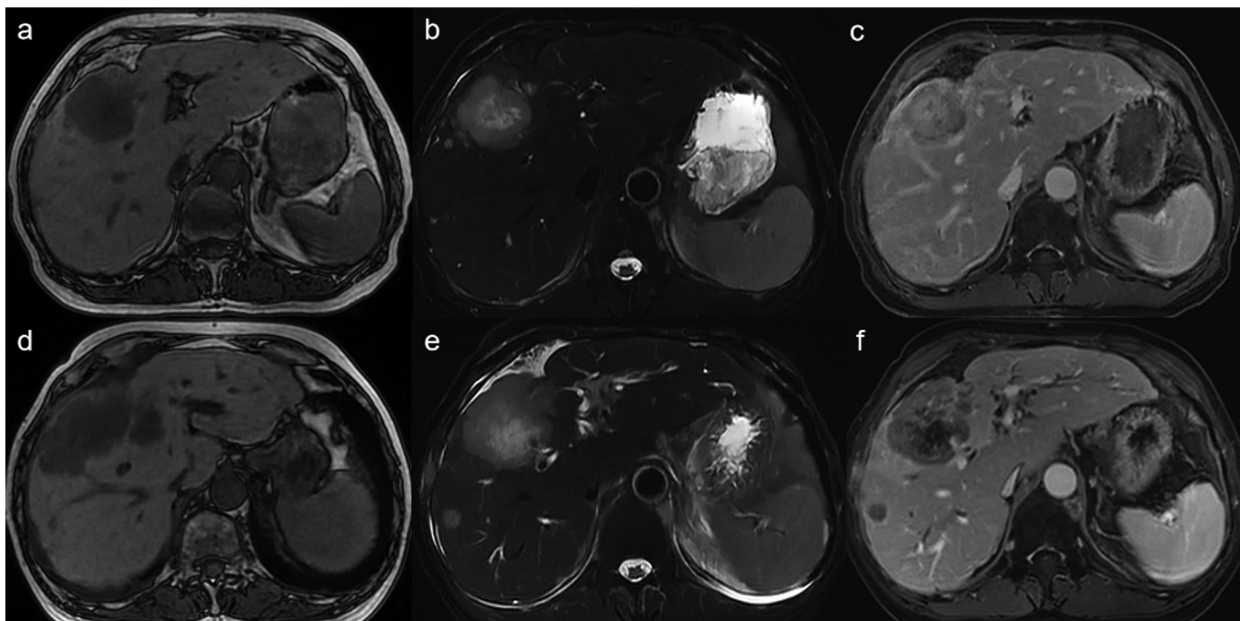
Comparison of efficacy in a patient with prostate neuroendocrine carcinoma and diffuse hepatic metastases. (A-C) Pretreatment: (A) Non-contrast T1-weighted, (B) non-contrast T2-weighted and (C) contrast-enhanced T1-weighted magnetic resonance images showing innumerable liver metastases. (D-F) Post-treatment: Corresponding (D) Non-contrast T1-weighted, (E) non-contrast T2-weighted and (F) contrast-enhanced T1-weighted sequences demonstrating >30% reduction in hepatic tumor burden consistent with a partial response.
